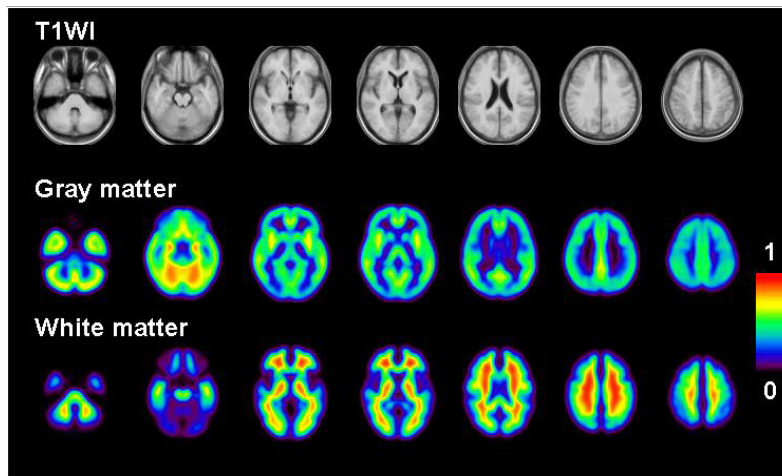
Anatomically standardized averaged T1-weighted MR images and gray and white matter images. Scale maximum and minimum values are 1 and 0 mI/mL, respectively, for both gray and white matter images.
